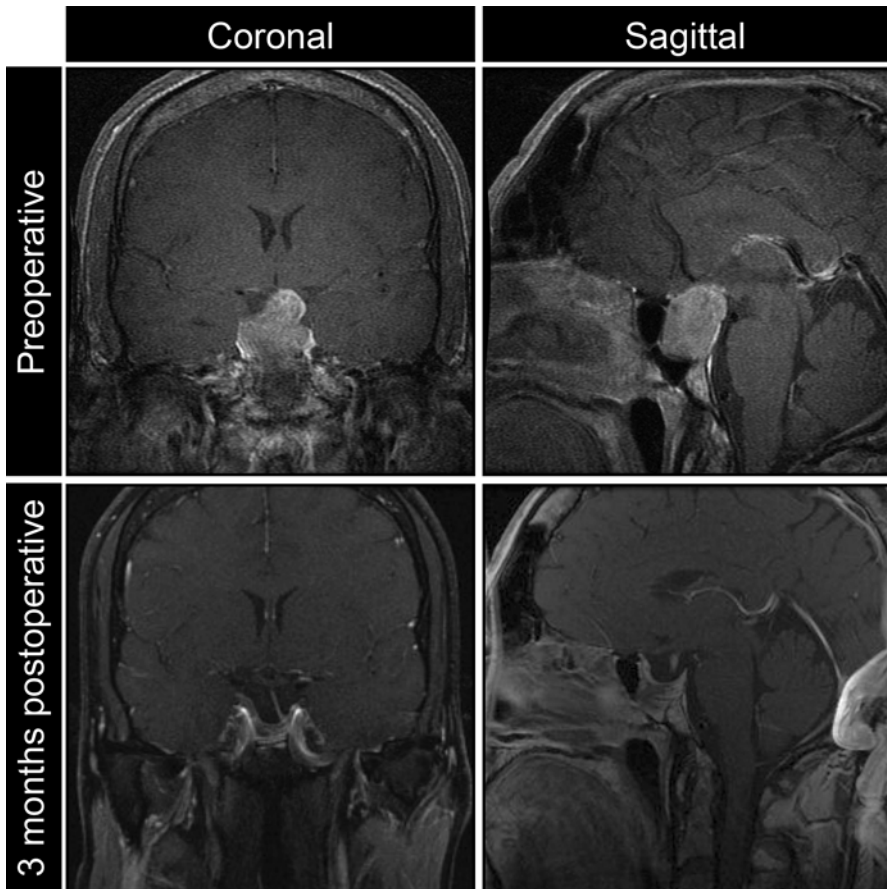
Contrast-enhanced T1-weighted coronal and sagittal MR images; preoperative and 3 months postoperative
